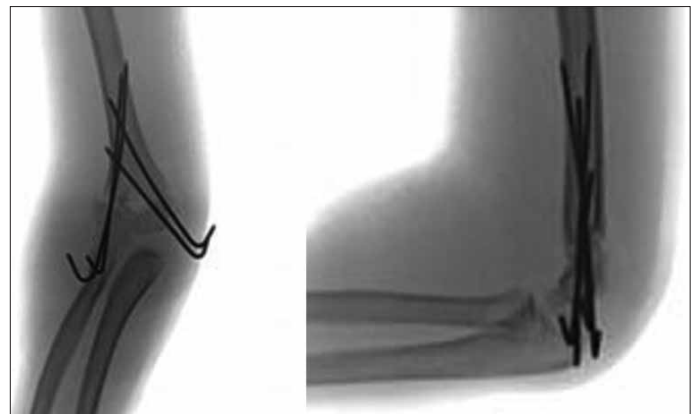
Postoperative X-rays (AP and lateral)
